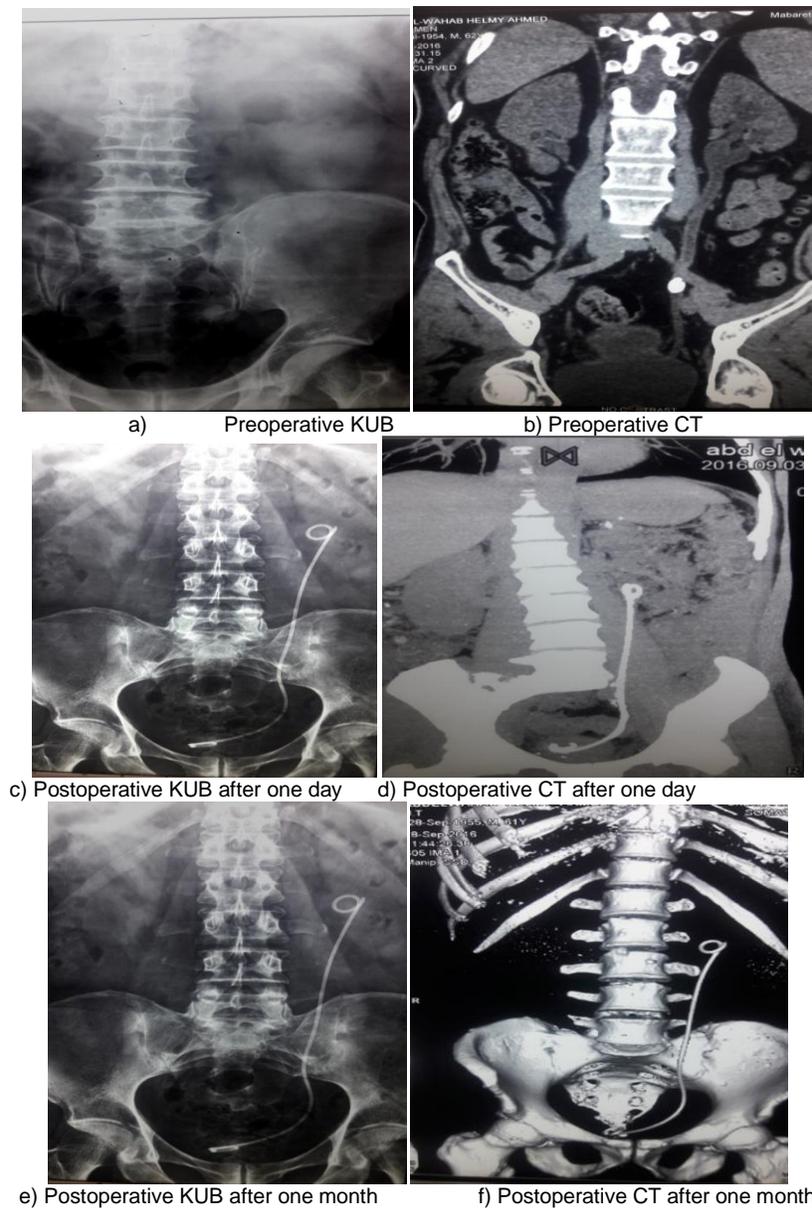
Male patient 55 years old. Ultrasound: Left moderate hydronephrosis .a) Plain KUB revealed stone Left distalureter. b) PelviabdominalCT: Left hydronephrosis and stone Left lower third ureter. Procedure: Ultrasonic lithotripsy with DJ insertion Follow up. c) Postoperative KUB after one day: residual stone <4 mm. d) CT: residual stone <4 mm.e) Postoperative KUB after one month: free. f) CT: residual stone after one month: free
